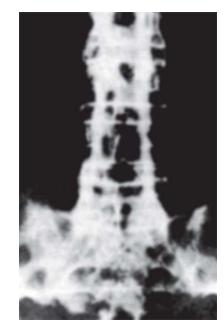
X-ray of LS spine showing bamboo spine in ankylosing spondylitis
